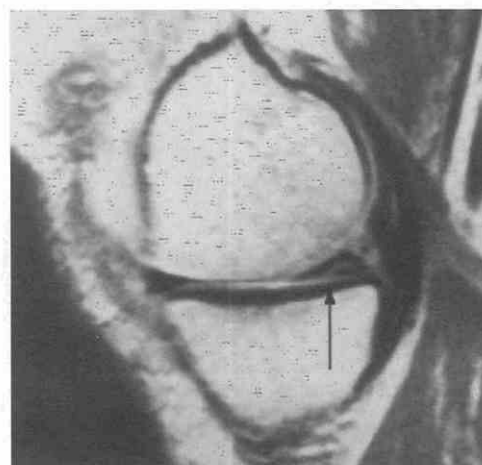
Nondisplaced meniscal tears. Sagittal T1-weighted image shows high signal intensity at the posterior horn of the medial meniscus extending to the inferior articular surface (*arrow*).
